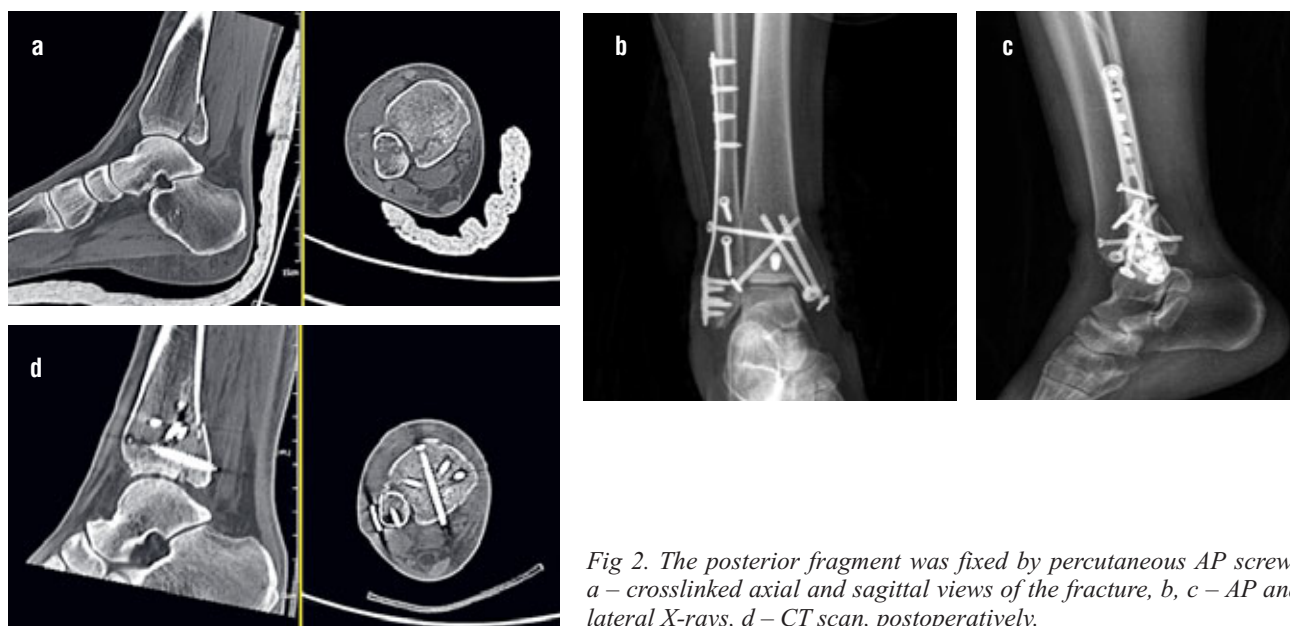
The posterior fragment was fixed by percutaneous AP screw: a – crosslinked axial and sagittal views of the fracture, b, c – AP and lateral X-rays, d – CT scan, postoperatively.
